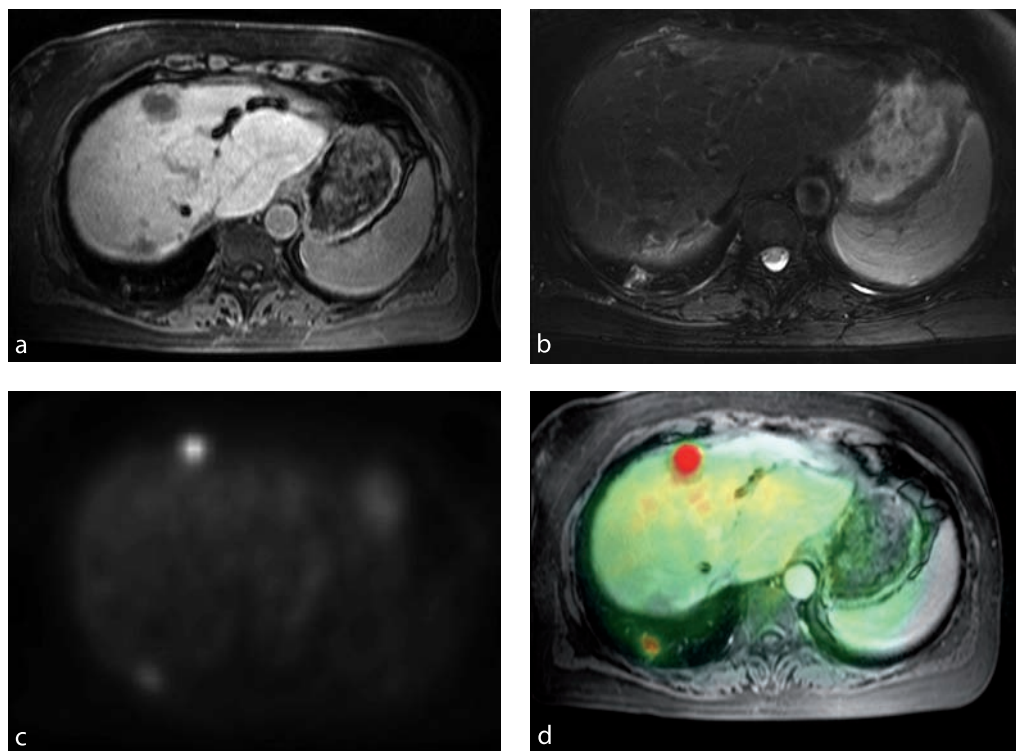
a Contrast-enhanced MRI of a patient with colorectal cancer and hemihepatectomy. Two new liver metastases were treated by radiofrequency ablation (RFA) 6 months ago. MRI was performed because of rising CEA level during follow-up. Contrast enhanced T1-W images demonstrate two hypointense scars after RFA. b On T2-W images, a hyperintense area close to the ventral scar is visualized, suggesting local recurrence. In addition, a hyperintense focal lung lesion is visible. c FDG-PET on axial orientation shows two hypermetabolic areas, both suggesting tumor activity. It remains unclear if the second focus is located in the lung or in the liver (Courtesy of Dr. Dresel, Chairman of the Dept. of Nuclear Medicine Robert-Rössle Klinik Charité Campus Buch). d Fusion of FDG-PET and MRI underlines local recurrence in the ventral liver lesion and the appearance of the new lung metastases. In contrast, no activity is visualized in the second liver lesion
